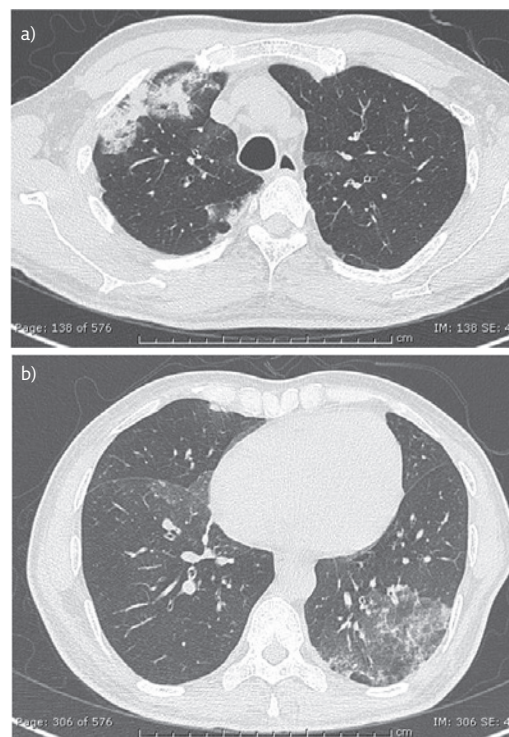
a and b) HRCT of the thorax reveals patchy areas of consolidation with surrounding ground-glass opacities and interlobular septal thickening predominantly in peripheral distribution involving both lungs.
